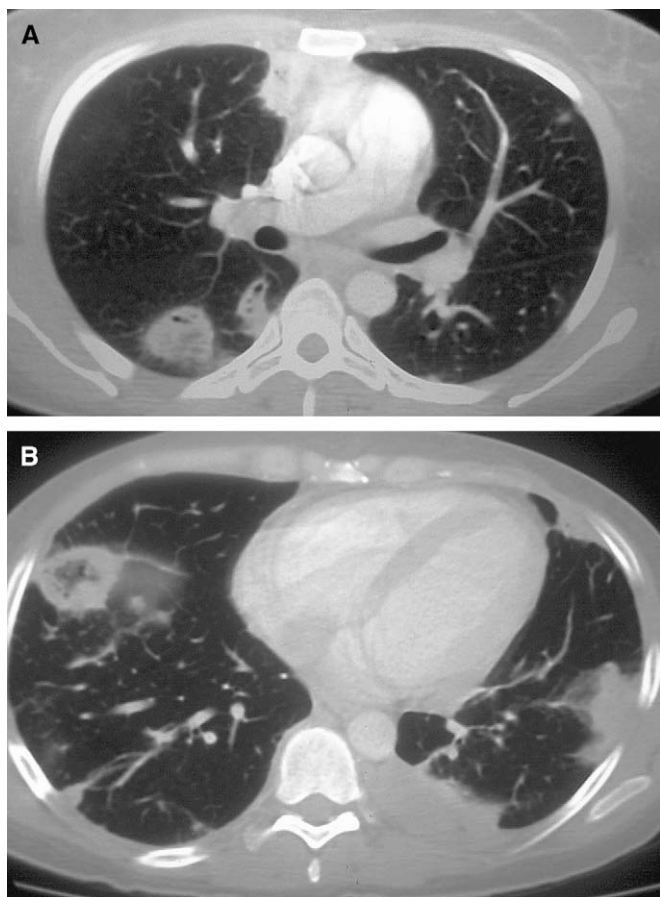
(A and B) Representative images from a transverse contrast-enhanced computed tomography through the thorax utilising lung windows. There are multiple cavitating lesions present throughout both lungs. Some focal atelectasis also is seen within the left base.
